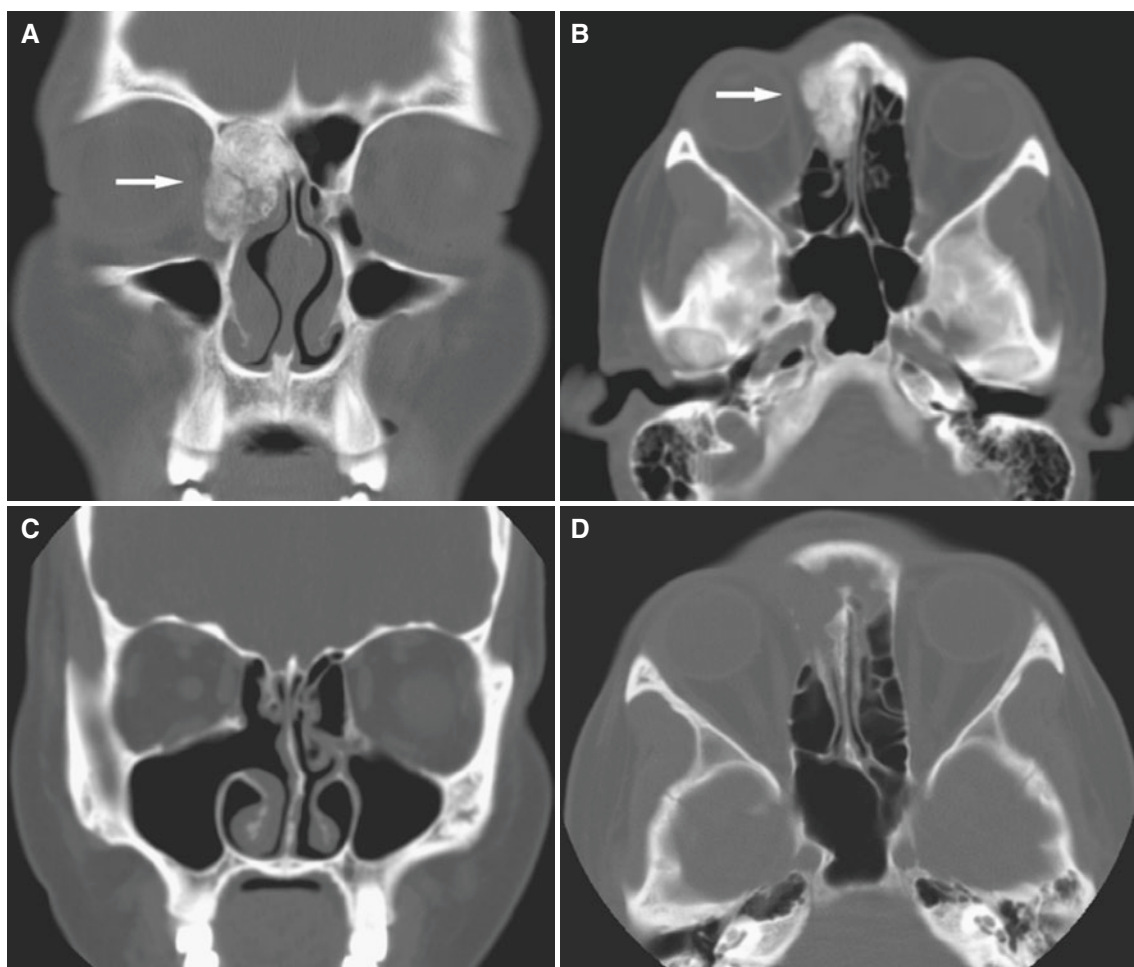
Frontal/ethmoid osteoma; 19-year-old female. (A) Coronal CT image shows well-defined bone mass in the right frontal and ethmoid sinuses crossing midline (*arrow*), with left ethmoid and maxillary sinuses normal. (B) Axial CT image shows osteoma extending to frontal recess of the maxilla anteriorly (*arrow*), with otherwise normal
